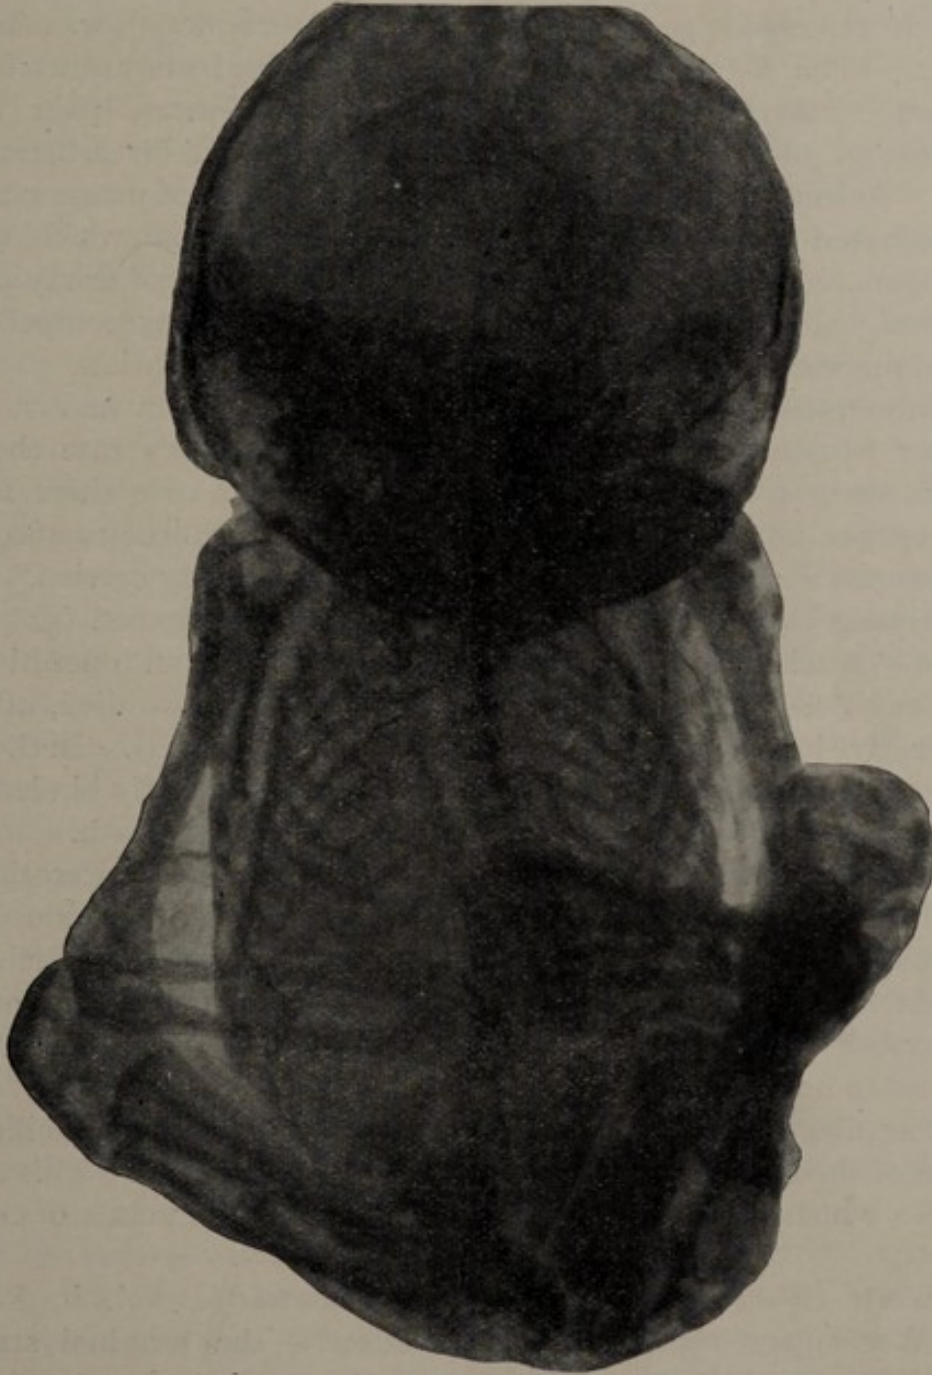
Radiograph of lithopedion.
